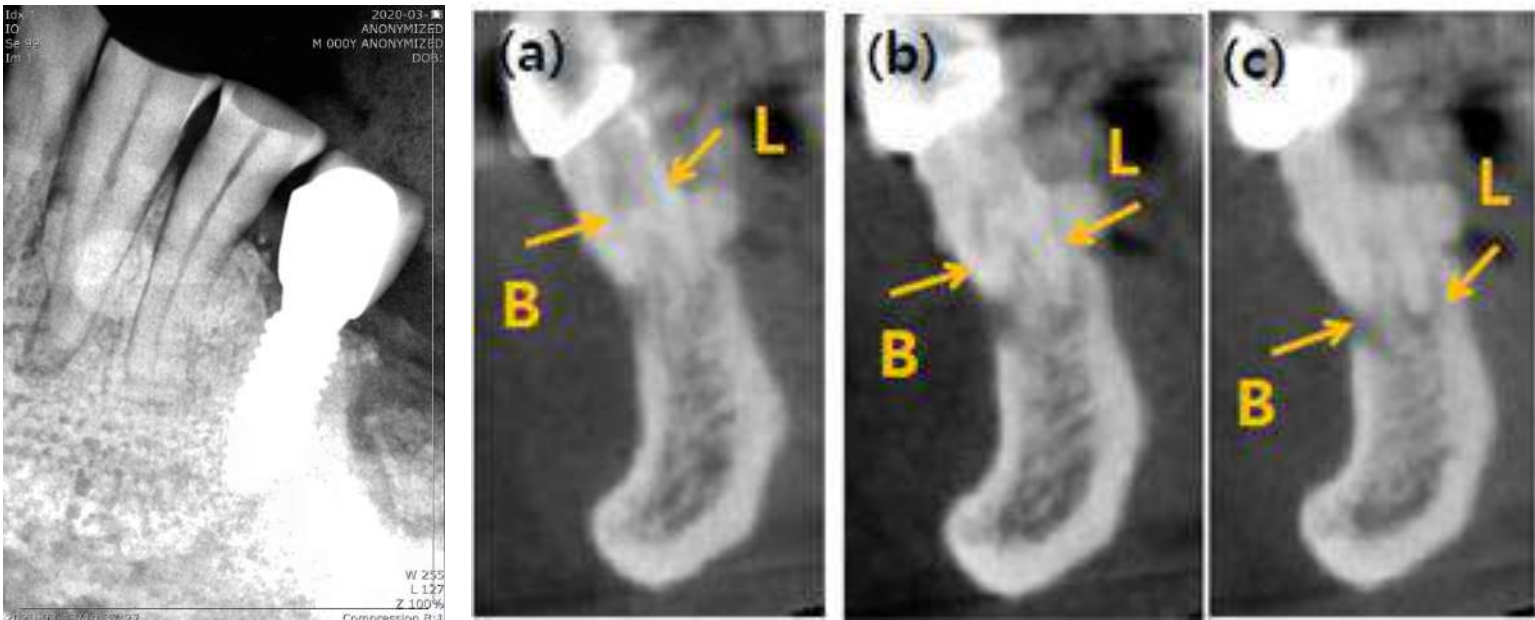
Radiography evaluation
